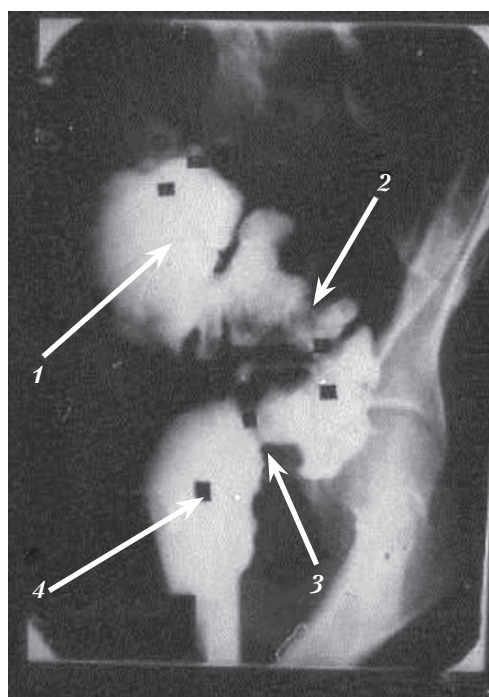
X-ray contrast study of the transit of barium sulfate in the large intestine. The alternation of functional segments of the large intestine filled with barium suspension and barium-free ones: 1, 2 – segments of the large intestine, free from barium suspension; 3, 4 – segments of large intestine filled with barium suspension
